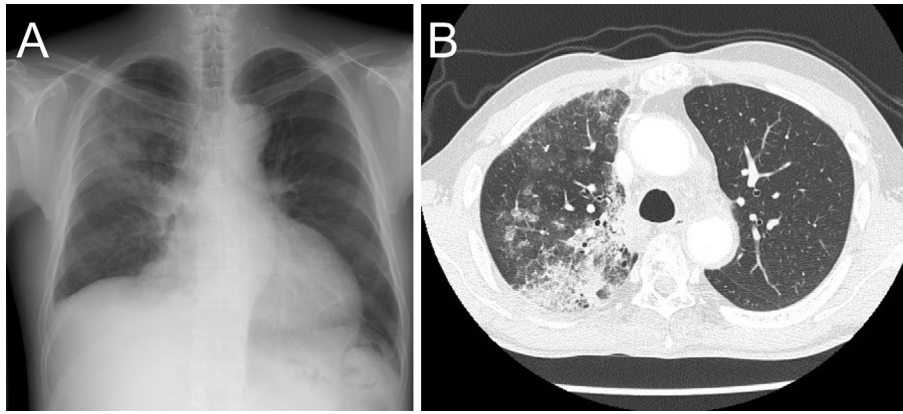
(A) Chest radiography on admission showing infiltrative shadows in the right lung field. The cardiothoracic ratio (55.7%) is high, and the right cardiopulmonary angle is slightly dull. (B) Chest computed tomography (lung window) showing ground-glass opacity and patchy shadows in the right upper lung field, suggesting pulmonary hemorrhaging. There is pleural effusion in the right thorax.
